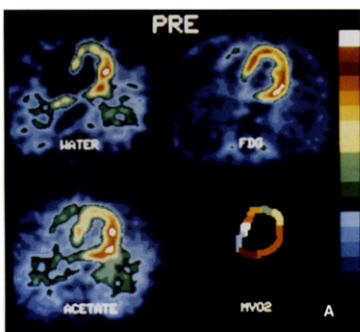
A, Reconstructions of myocardial perfusion and metabolism before (PRE) coronary revascularization in the heart of Subject 12, who was subsequently found to have viable myocardium in the anterior wall. Before revascularization, utilization of glucose (FDG) in the anterior wall was equivalent to that in the normal posterolateral wall despite the presence of mild anterior wall hypoperfusion. Although myocardial oxygen consumption (MVO₂) in the anterior wall was decreased relative to that in the normal posterolateral wall, the magnitude of the reduction is less than that in Figure 3. B, After (POST) revascularization, values for regional myocardial perfusion, utilization of glucose and oxidative metabolism in the anterior wall were comparable to values in normal myocardium.
